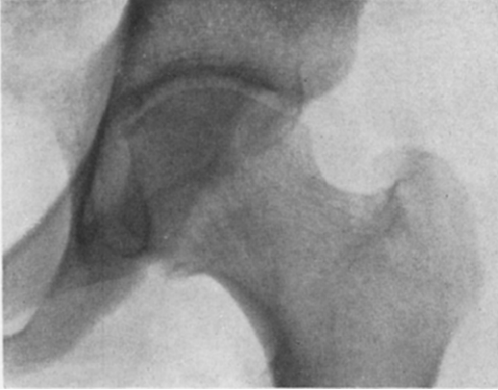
Case xxii. Roentgenogram June 9, 1937; partly separated sequestrum in acetabulum; compression focus in head.
